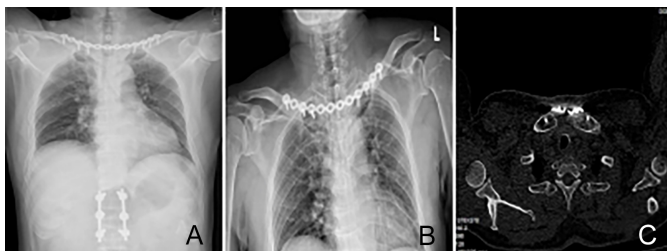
(A) X-ray film taken during the postoperative examination. (B) X-ray film taken approximately 2 months after the operation. Callus has formed at the proximal end of the left clavicle, and the fracture line is blurred. (C) The fracture of the medial end of the left clavicle has healed 6 months after the surgery.
